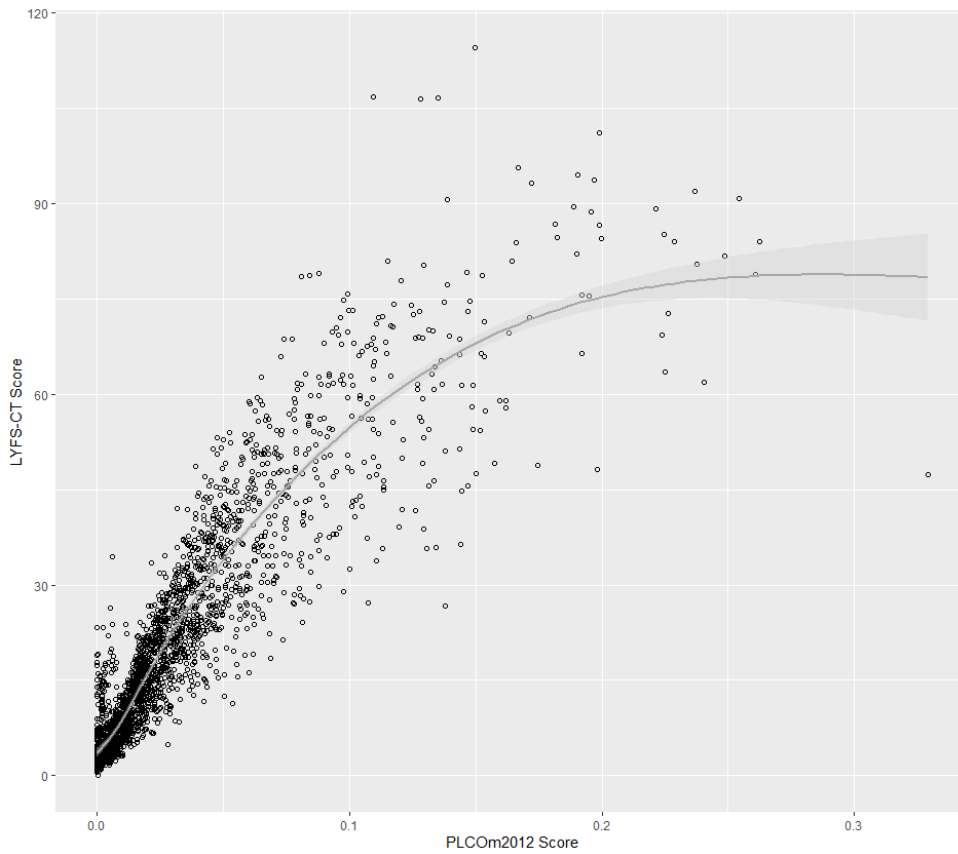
PLCO_{M2012} scores vs. LYFS-CT scores for complete LHC pilot cohort. PLCO_{M2012} scores presented in proportion form as this is how the *lcmodes* package generates the scores. These were converted to percentages in the descriptions to retain consistency with other chapters.
